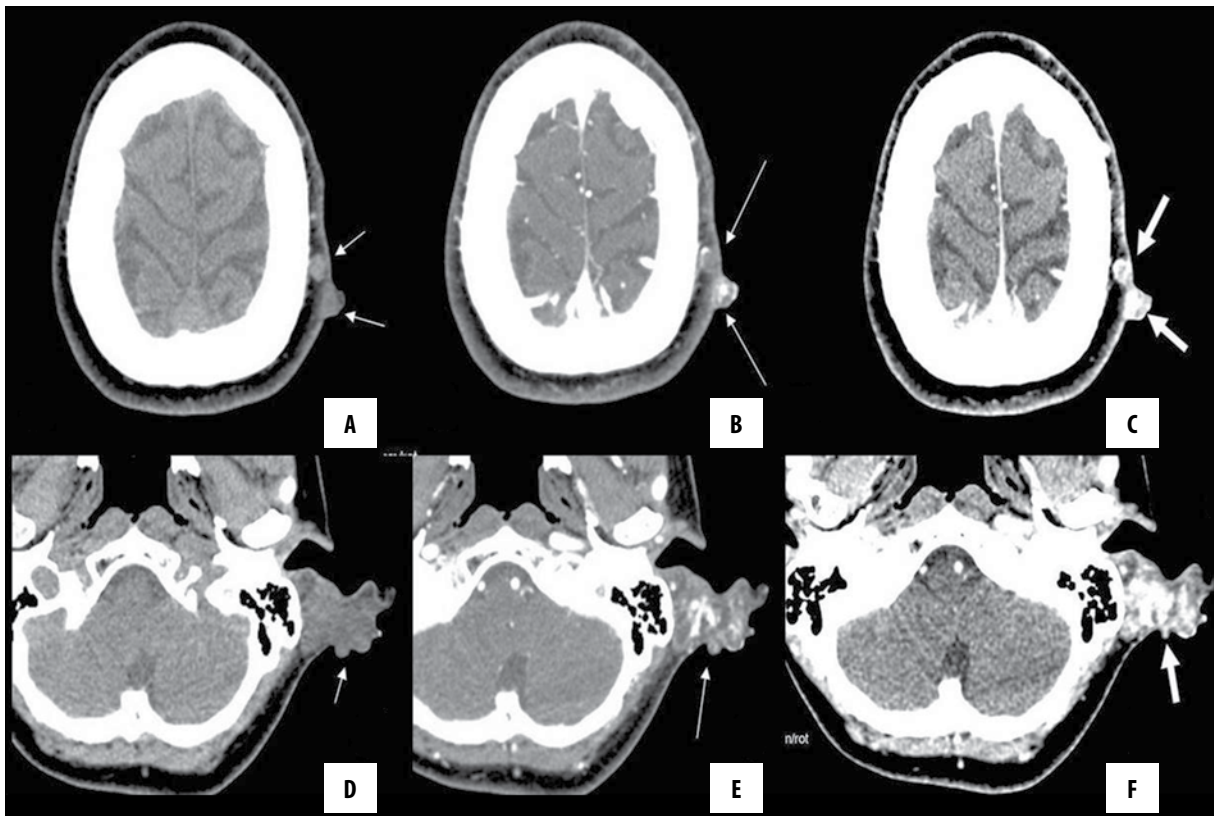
On dynamic CT examination, axial sections showed a characteristic contrast retention in the nodular lesions on the scalp. On the sections near vertex (A–C) and through the left ear (D–F) the lesions are hypodense in pre-contrast images (short arrows), there is central or eccentric contrast retention in the arterial series (long arrows) and heterogeneous hyperdensity in the venous series (thick arrows).
